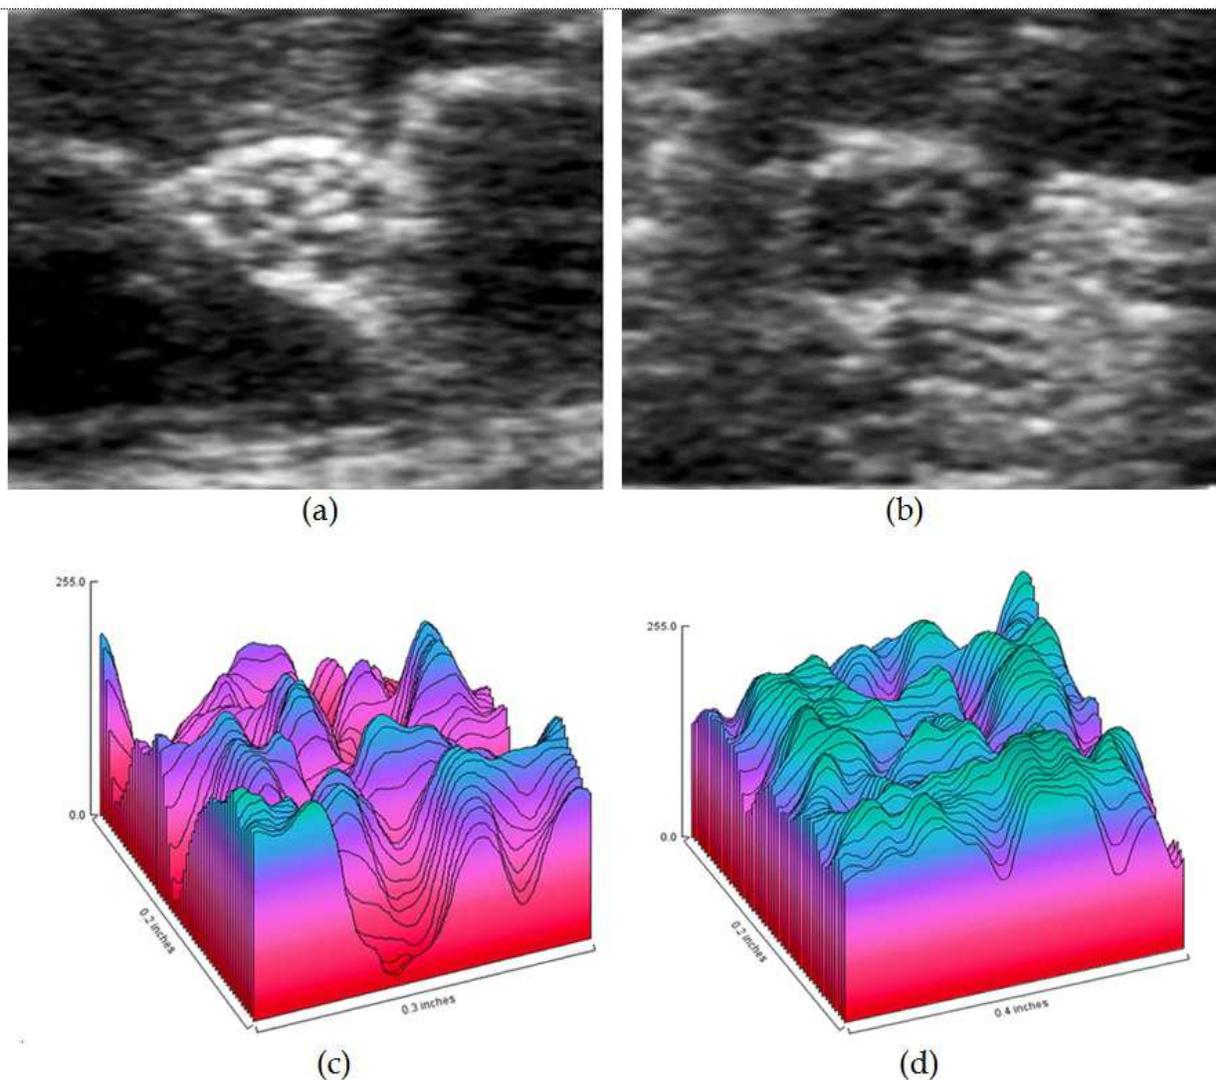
Distributions of the echo intensity in the median nerve. Transverse sonogram of the median nerve in a control participant's wrist (a). Transverse sonogram of the median nerve in a diabetic patient's wrist (b). Three-dimensional graphic of the distribution of the echo intensity in the control's wrist (c). Three-dimensional graphic of the distribution of the echo intensity in the diabetic patient's wrist (d). Hypoechoic area was displayed "light blue", and hyperechoic area was displayed "pink".
